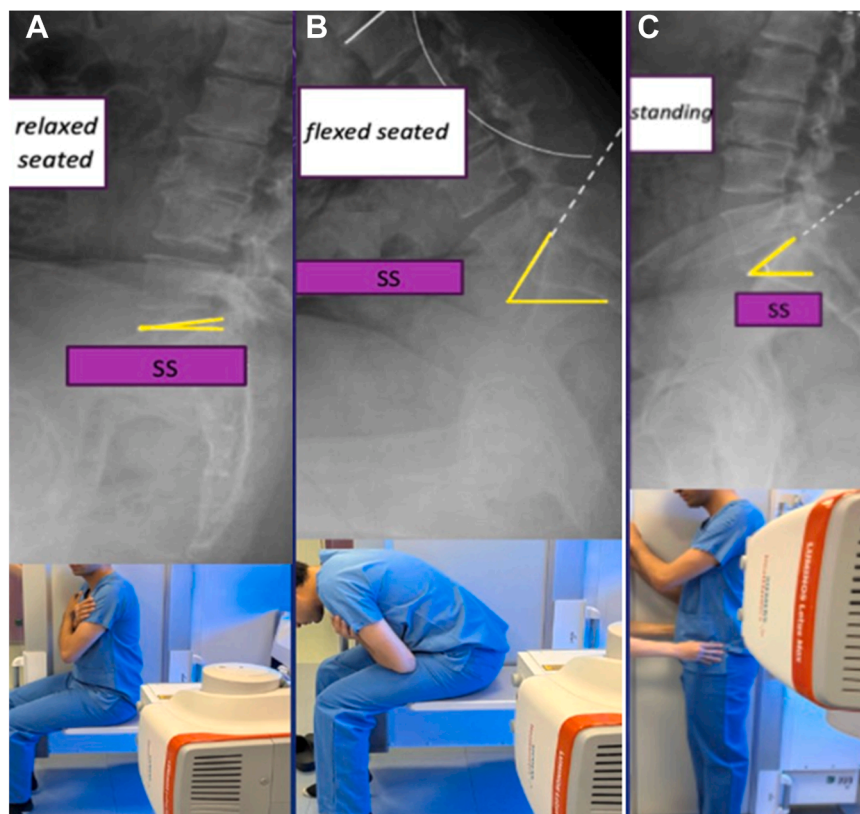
Standardized spino-pelvic radiographic protocol demonstrating the following three imaging positions: (A) relaxed-seated, with the patient sitting upright and hips and knees flexed to approximately 90°; (B) flexed-seated, with forward flexion from the hips to a comfortable maximum; and (C) standing, with the patient upright. All images were obtained using the same radiographic setup with consistent beam centring at the S1 endplate.
